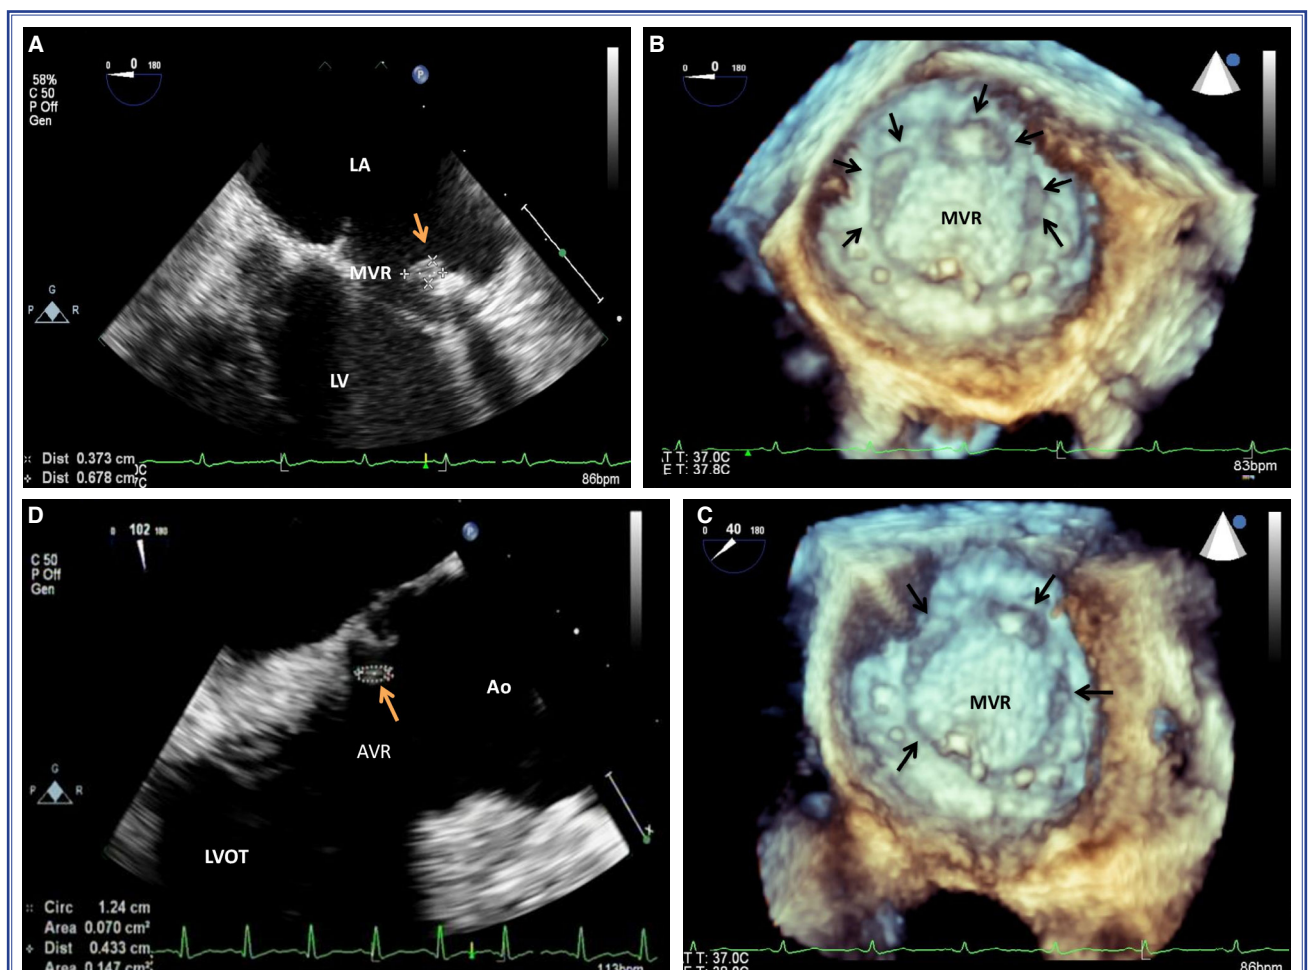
(A) Two-dimensional transesophageal echocardiography (TEE) imaging shows a nonobstructive aortic prosthetic valve thrombus with a total area of 0.25 cm². (B) Real-time 3-dimensional TEE shows a nonobstructive mitral prosthetic valve thrombus with a total area of 0.67 cm² (0.25 cm²+0.30 cm²+0.12 cm²). (C) Three-dimensional TEE image demonstrating a nonobstructive mitral prosthetic valve thrombus. (D) Two-dimensional TEE image of a nonobstructive aortic prosthetic valve thrombus with a total area of 0.07 cm².
